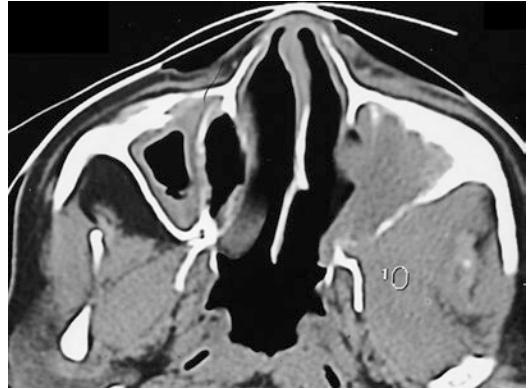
CT scan shows a left maxillary sinus pathology with destruction of its posterior wall and an infra-temporal bone involvement
